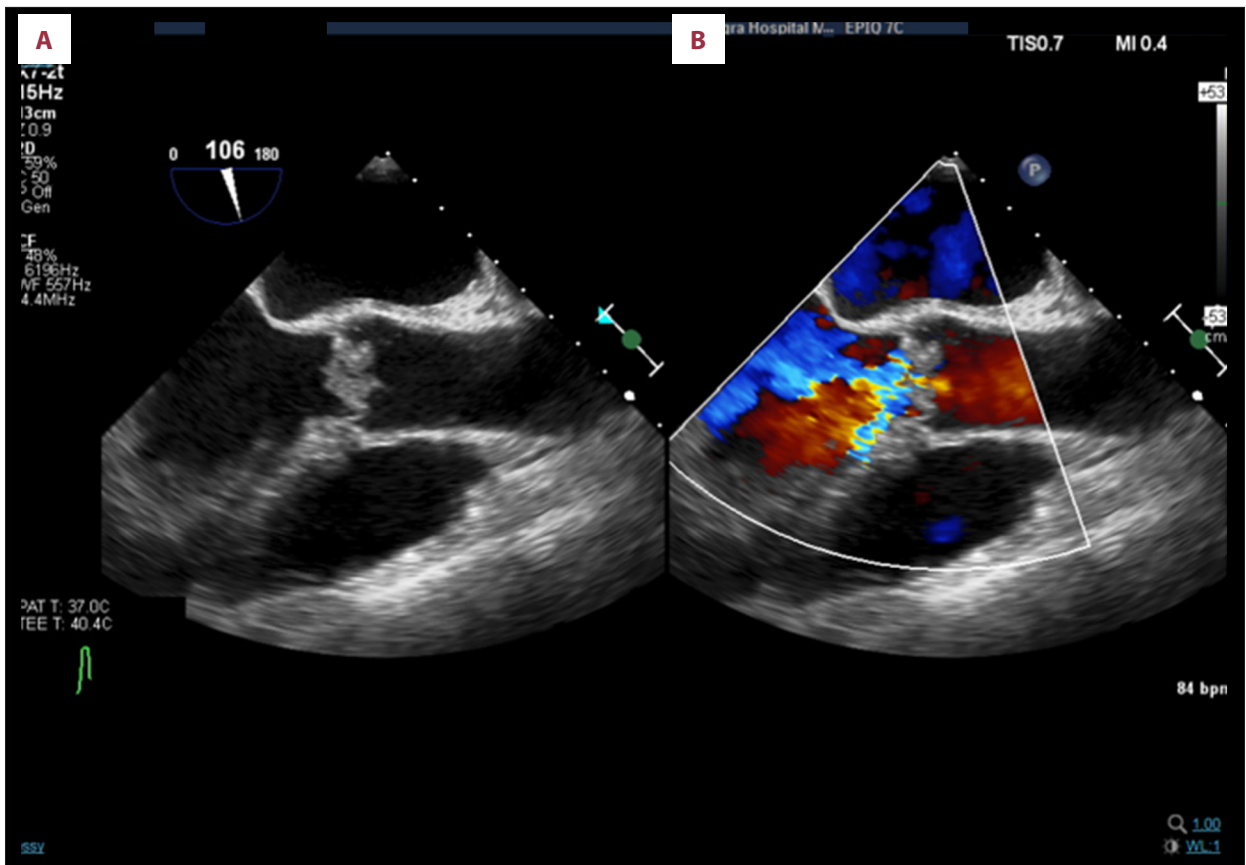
Paraseptal view on transesophageal echocardiography (TEE) with color doppler demonstrating severe aortic regurgitation (A) with thickened aortic valve leaflets (B) and approximately 1 cm sized mobile aortic valve lesion.
